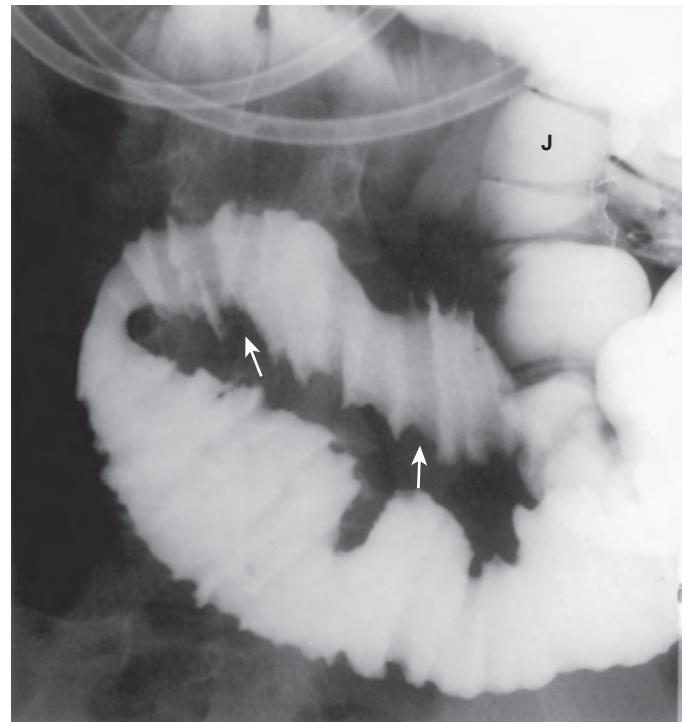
Ulcerative jejunoileitis complicating celiac disease. This spot radiograph during the early phase of enteroclysis shows a loop of jejunum with moderately thickened, irregular folds (arrows) caused by ulcerative jejunoileitis. Also note a decreased number of normal-sized folds more proximally in the jejunum (J) because of underlying celiac disease. (From Rubesin SE, Herlinger H, Saul SH, et al: *Adult celiac disease and its complications*. RadioGraphics 9:1045–1066, 1989.)
